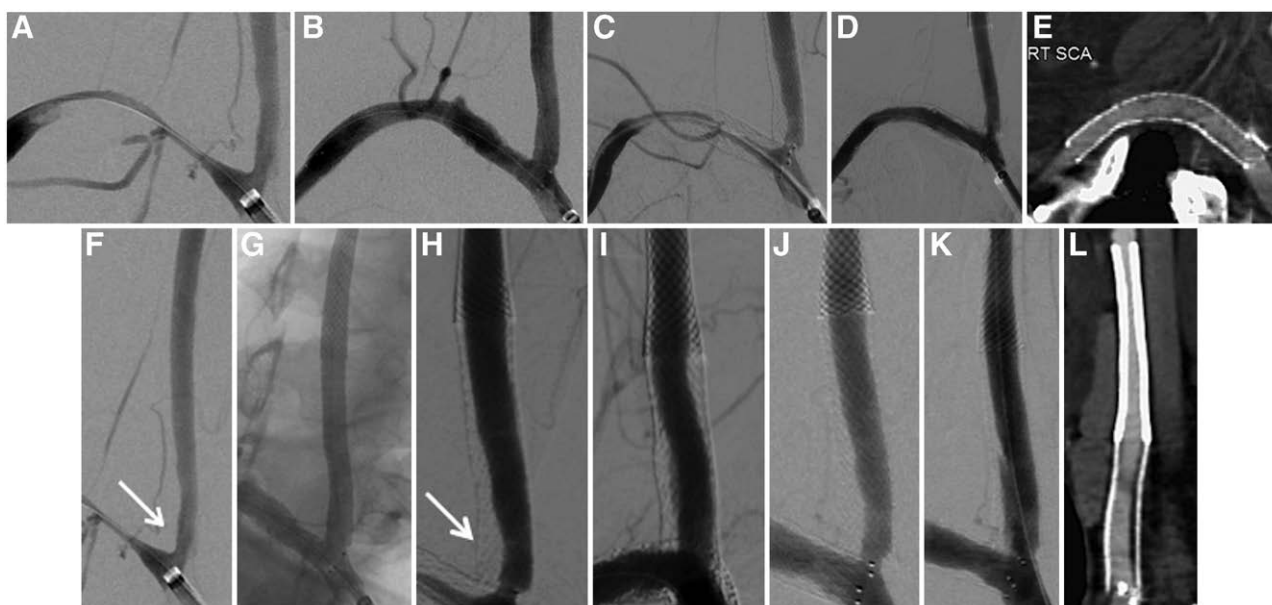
A 36-year-old female with TA who experienced ipsilateral limb ischemia and visual impairment underwent PTAS in the right subclavian artery (A–E) and right CCA (F–L). A, Initial angiogram shows 95% stenosis in the right subclavian artery. B, Control angiogram after the first PTAS. C, At 1-year follow-up, in-stent restenosis is observed. D, Control angiogram after DEB angioplasty. E, CTA with curved multiplanar reconstruction (MPR) was performed at 32-month follow-up and the right subclavian artery appears patent. F, Initial angiogram shows 50% stenosis in the right proximal CCA (arrow). G, Control angiogram after the first PTAS. H, At 1-year follow-up, in-stent restenosis is observed (arrow). I, Control angiogram after uncoated balloon angioplasty. J, Follow-up angiogram at 5 months after uncoated balloon angioplasty shows restenosis at a proximal site. K, Control angiogram after DEB angioplasty. L, CTA with curved MPR was performed at 27-month follow-up and the right CCA appears patent. CCA = common carotid artery; CTA = computed tomography angiography; DEB = drug-eluting balloon; PTAS = percutaneous angioplasty and stenting; TA = Takayasu arteritis.
